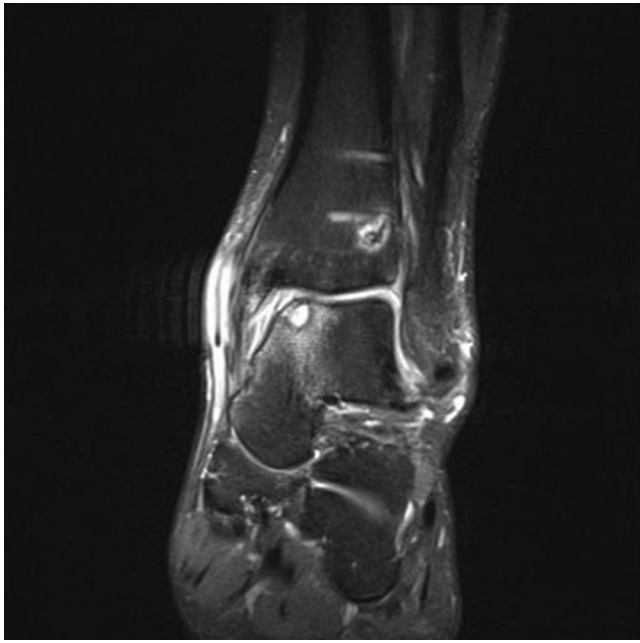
Preoperative magnetic resonance image, coronal view, of medial osteochondral lesion.
